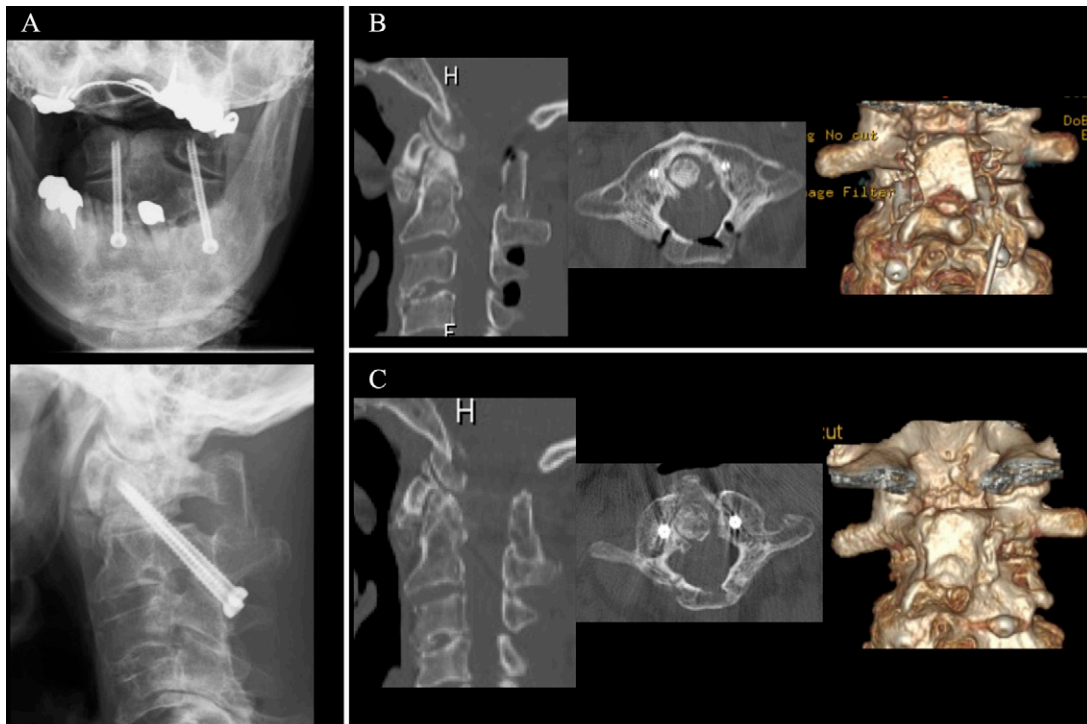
Postoperative radiographs and CT scans. A: Radiographs revealed appropriate bilateral screw implantation using the Magerl technique. B: CT showed C1 double-door laminoplasty and interlaminar autogenous iliac bone implantation immediately after surgery. C: CT revealed satisfactory posterior bone union between the C1 and C2 levels 6 months after surgery.
